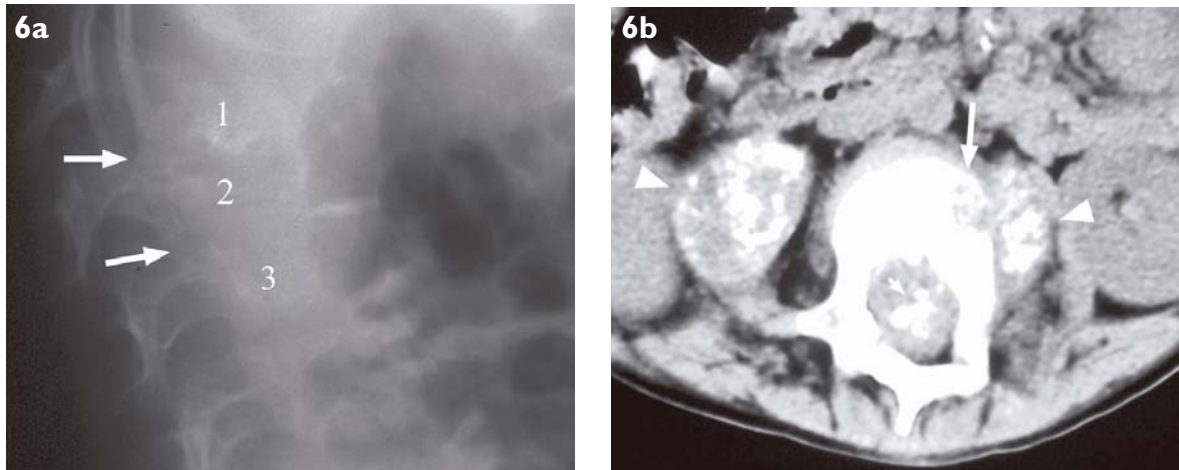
Collapsed vertebral body in 10-year-old child with L1-3 TB spondylitis. a) Lateral radiograph of the lumbar spine shows collapse of L1, L2 and L3 vertebral bodies. The L1/2 and L2/3 intervertebral disc spaces are also narrowed and poorly-delineated (arrows). b) Axial CT image taken through the L2 vertebral body shows a large erosion in the left side of the vertebral body (arrow). Calcifications are noted in both psoas muscles (arrowheads). Calcified soft tissue is also seen within the spinal canal, causing compression (small arrow).
